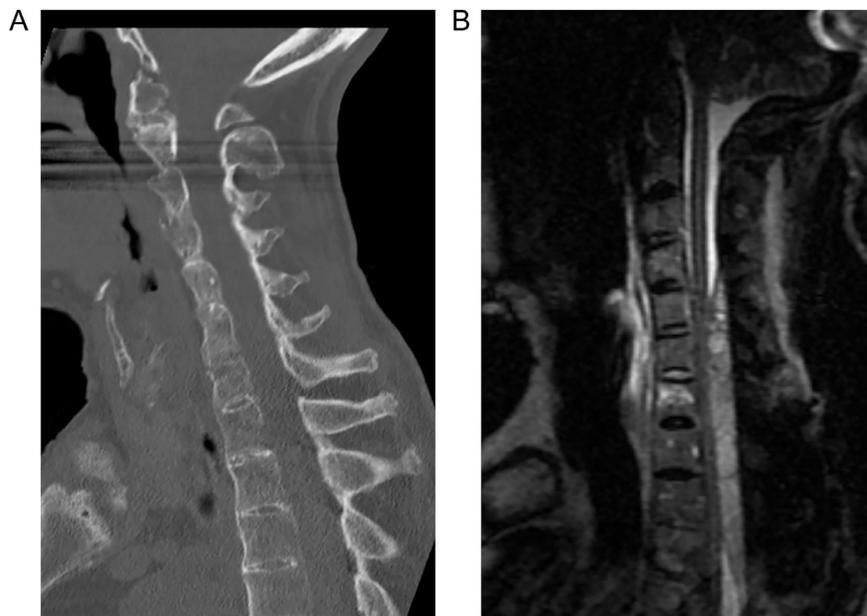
(A) Cervical CT reported no evidence of acute fracture or dislocation or subluxation. No abnormal widening of the disc spaces. No prevertebral soft tissue contour abnormality. (B) Cervical MRI shows transverse fracture in the C7 vertebral body. There is compression and displacement of the cord anteriorly by a large posterior epidural hematoma extending from C5 through T4, largest at C7 level.
